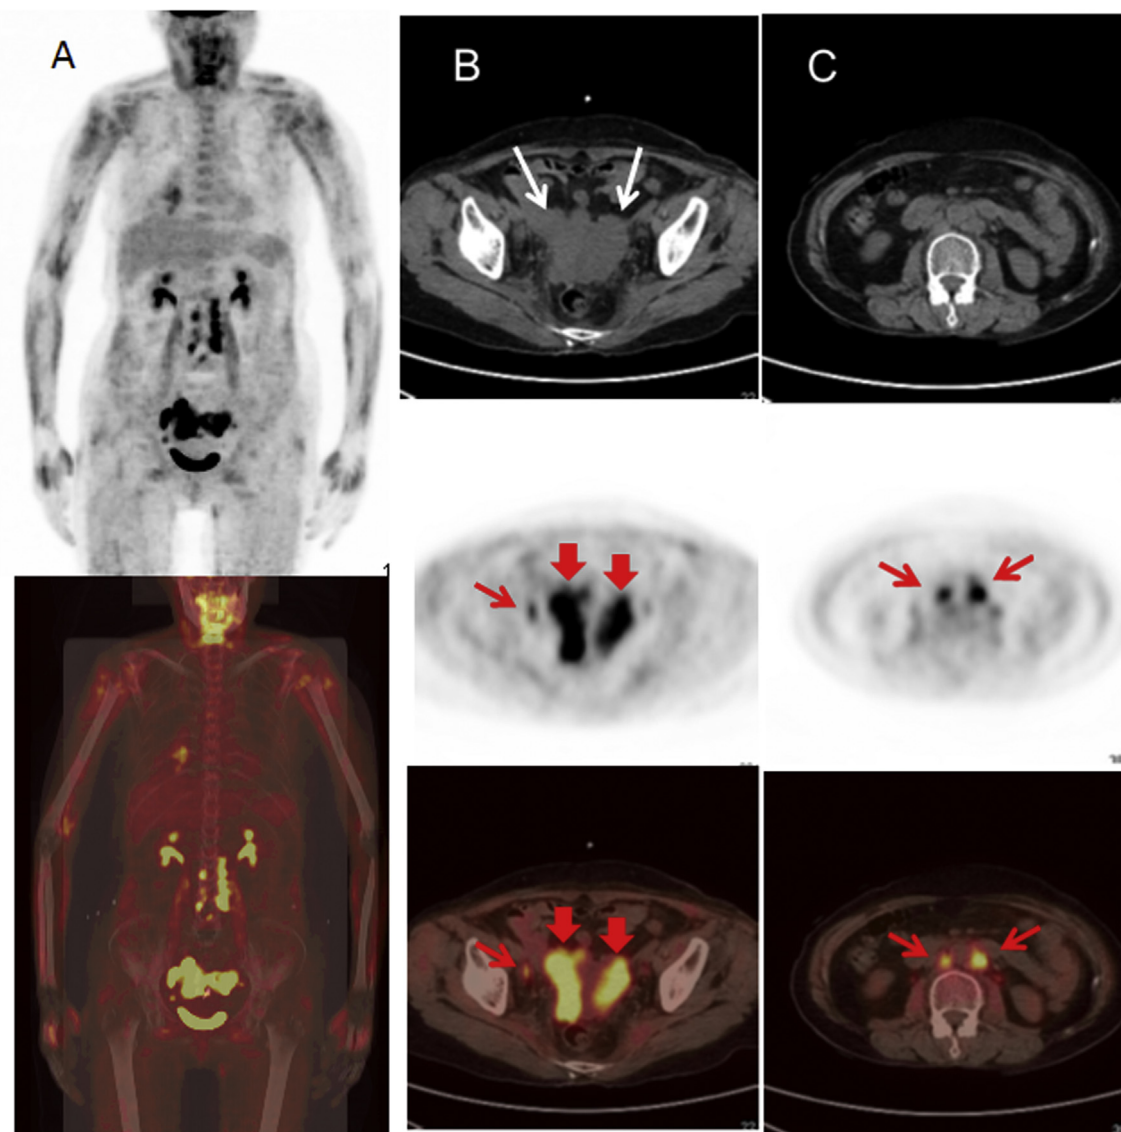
A 61-year-old female was diagnosed with dermatomyositis ([Table 1](#), No 5). A, PET/CT images showed increased ^{18}F -FDG uptake in muscles. B–C, CT images showed bilateral ovarian masses (white arrows). Marked ^{18}F -FDG uptake can be seen in bilateral ovarian masses (red thick arrows), pelvic and post-peritoneal lymph nodes (red thin arrows). Bilateral ovarian cancer with pelvic and post-peritoneal lymph node metastasis was considered. The pathological result showed it was ovarian adenocarcinoma.
